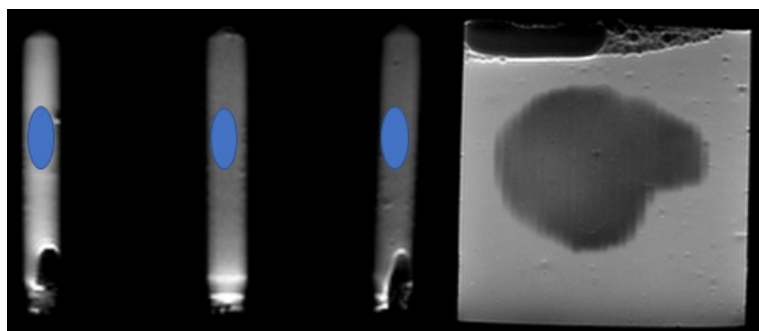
Acquired MRI images corresponding to cuboid B. Left: calibration vials, right: slice at approximately 0.5 cm depth in cuboid B.
